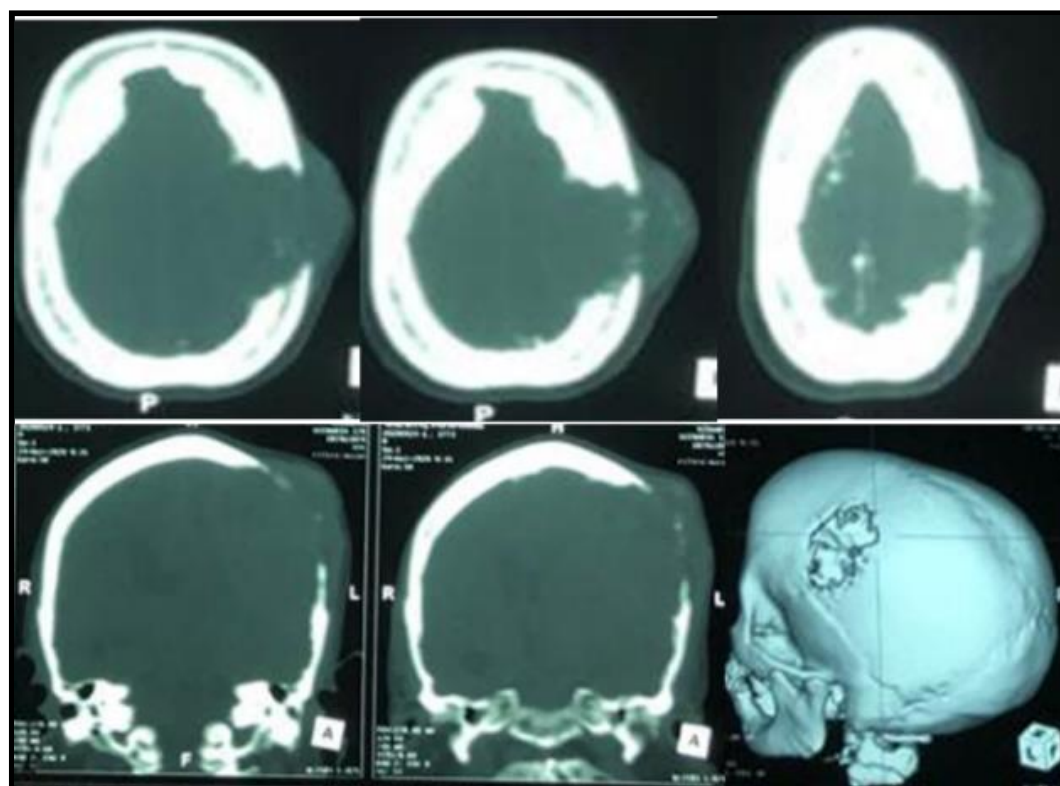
Cerebral CT scan with bone window, axial sections with coronal (A), sagittal and 3D (B) reconstructions.
